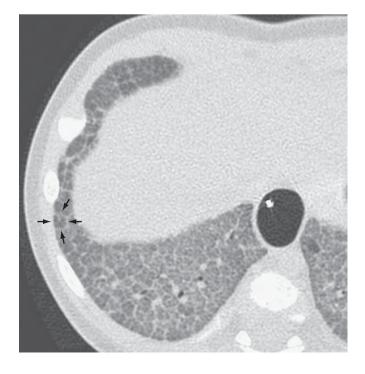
Detail seen with high-resolution computed tomography (HRCT): 3-month-old boy with chronic respiratory distress. HRCT image demonstrates interlobular septal thickening with diffuse ground-glass opacification. Note the visualization of secondary pulmonary lobules (*arrows*) in this patient with alveolar proteinosis.
